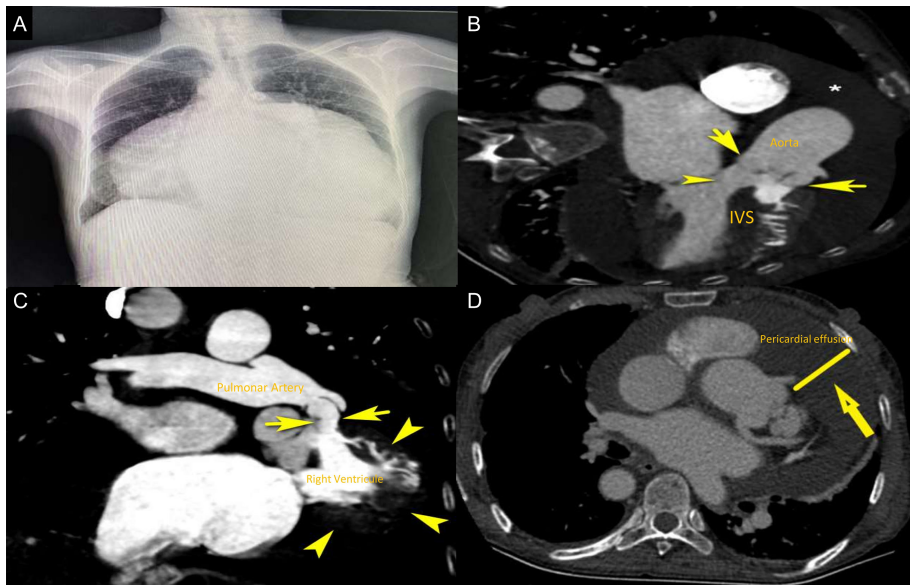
Chest x-ray shows a heart silhouette with a bottle-like appearance with an increased cardiothoracic ratio (A). Computed tomography depicts an overriding aorta (arrows) (B), perimembranous ventricular septal defect, subpulmonic valve stenosis and right ventricle hypertrophy (arrowheads) (C), and a large pericardial effusion (D). IVS, interventricular septum.
